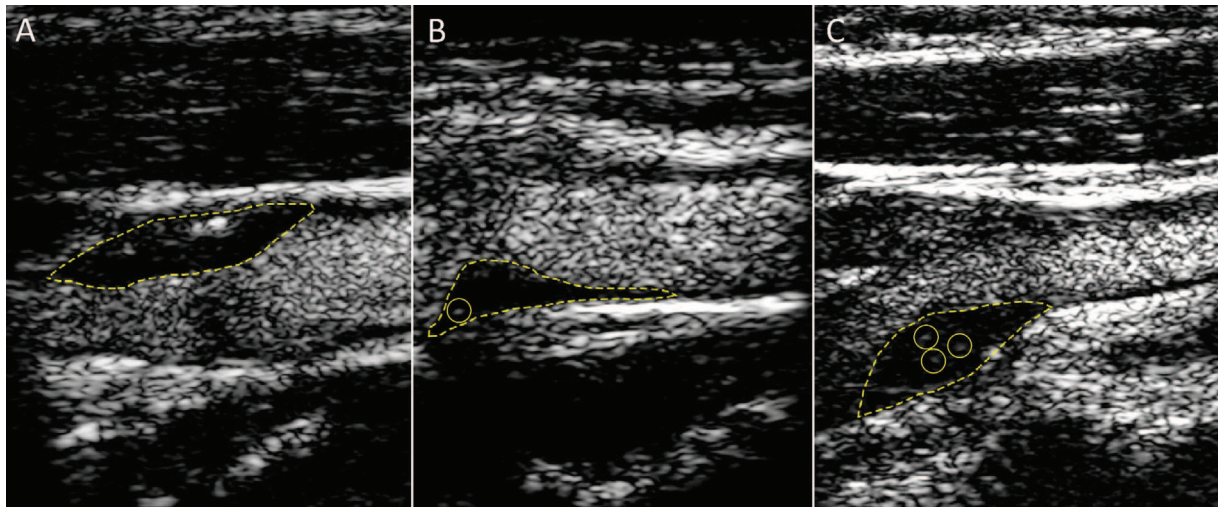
Contrast-enhanced carotid ultrasound for the detection of plaque neovascularization. Adapted from Mantella *et al.*⁶⁰ with permission. Carotid intraplaque neovascularization scoring method. Representative contrast-enhanced ultrasound images of carotid plaques. (A) demonstrates a plaque score of 0, no visible microbubbles within the plaque; (B) demonstrates a plaque score of 1, minimal microbubbles confined to peri-adventitial area; (C) demonstrates a plaque score of 2, microbubbles present throughout the plaque core. The yellow dotted line outlines the plaque lesion. Yellow circles depict intraplaque contrast microbubbles.
